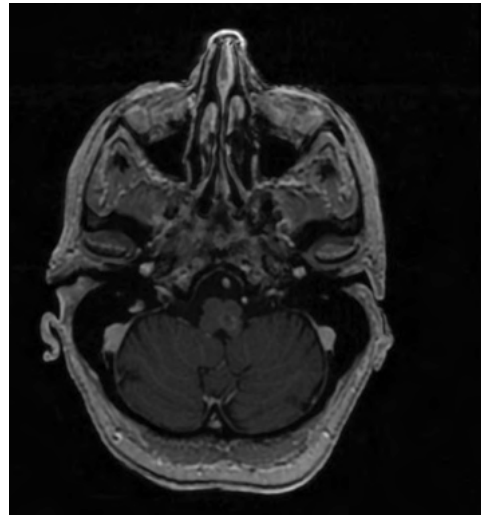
Axial postcontrast T1-weighted brain MRI shows a contrast-enhanced lesion in the left posterolateral medulla oblongata
